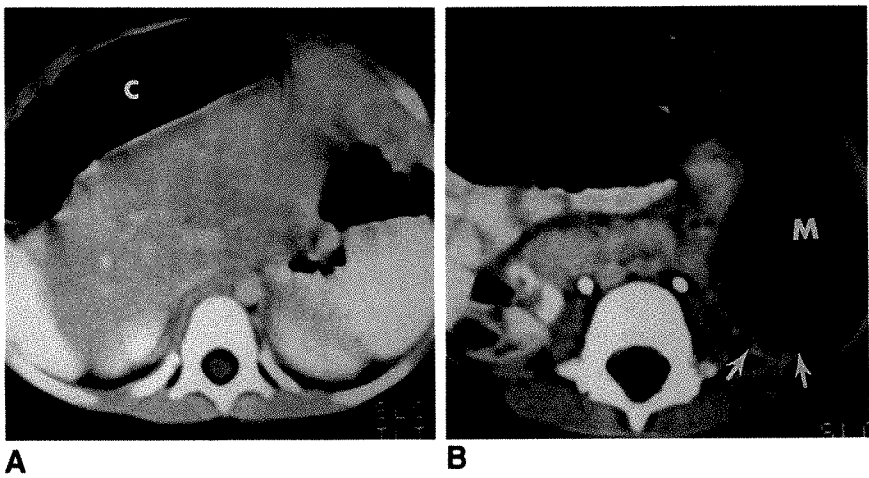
A, CT scan at level of upper poles of kidney shows absence of splenic tissue. An air-filled dilated transverse colon (C) is present anterior to liver, reflecting a marked ileus.
